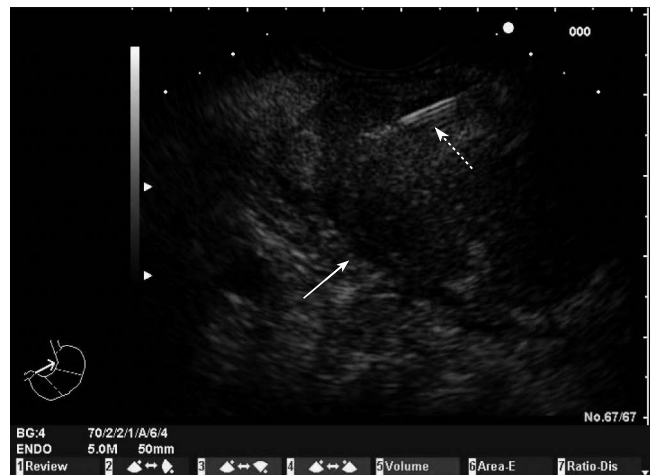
Endoscopic ultrasound image of a mass in the body of the pancreas. Fine needle aspiration of the mass (White arrow: pancreatic mass; Dotted arrow: FNA needle).
